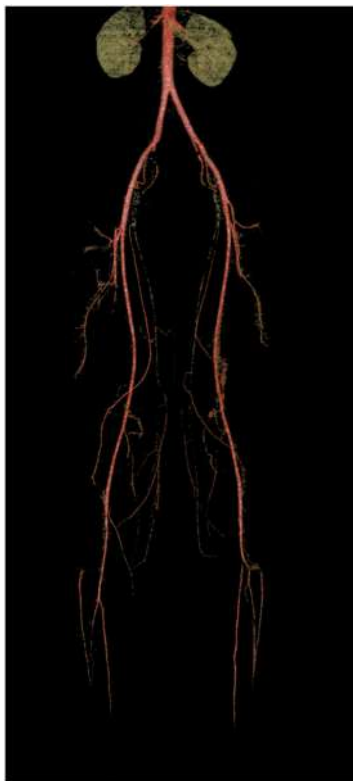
Computed tomography angiogram reconstructions demonstrating intact major vessel with spasm of pedal arteries bilaterally.
